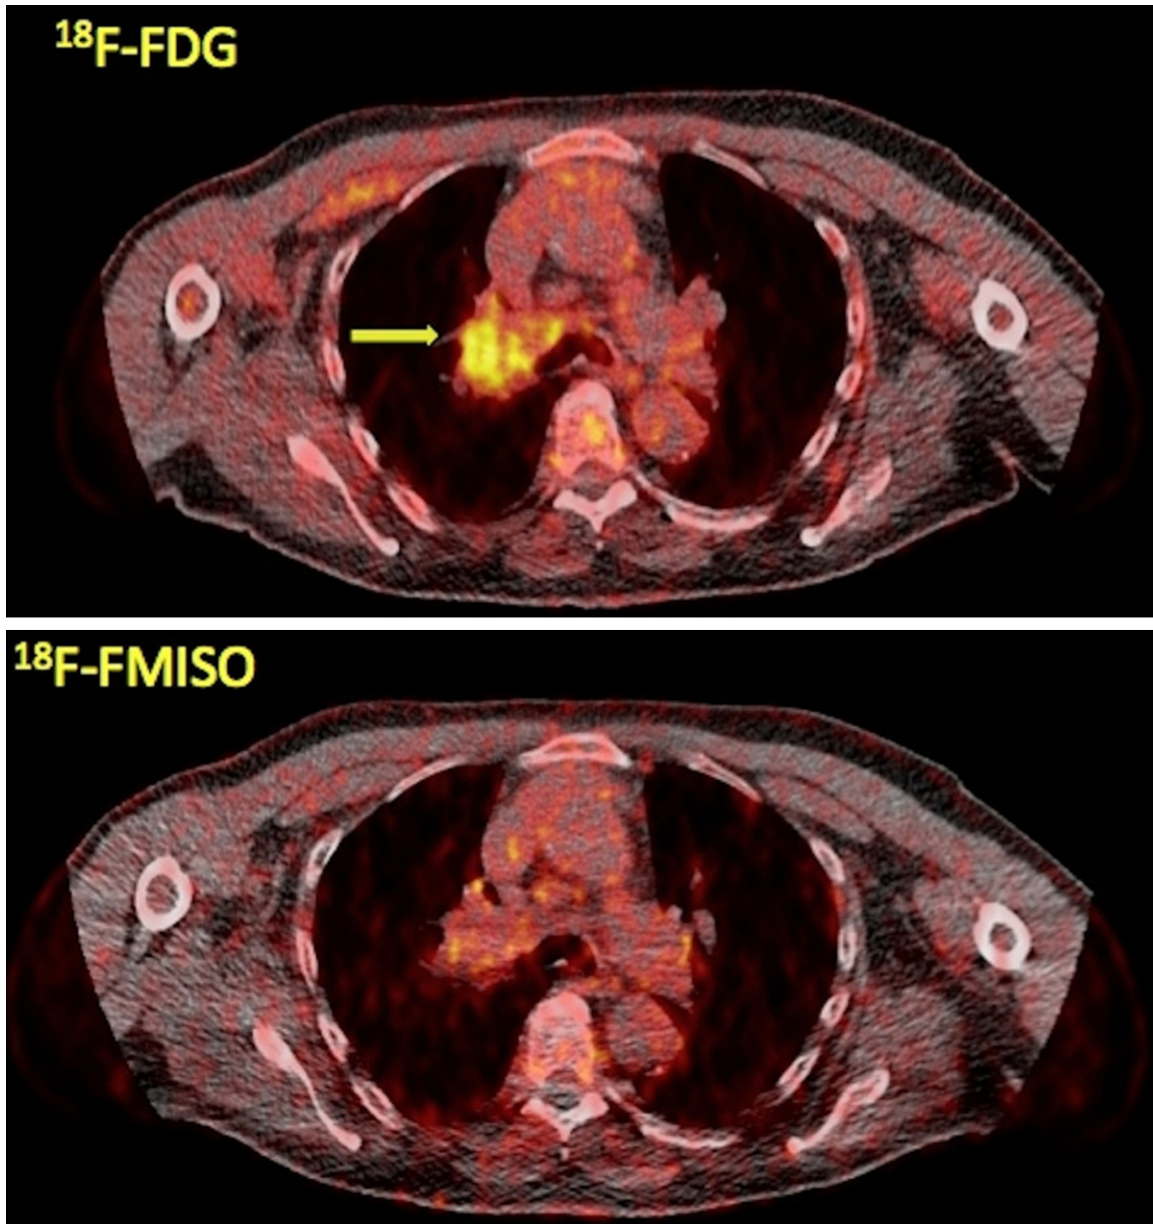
A 70-year-old male stage IIIB lung cancer patient referred to our department for PET/CT evaluation. Transaxial PET/CT images at the level of the lungs reveal the tumor in segment 3 of the right lung with enhanced ^{18}F -FDG uptake (upper row, arrow; $\text{SUV}_{\text{average}} = 3.2$, $\text{SUV}_{\text{max}} = 5.0$) but with faint ^{18}F -FMISO accumulation (lower row; $\text{SUV}_{\text{average}} = 1.5$, $\text{SUV}_{\text{max}} = 2.1$).
